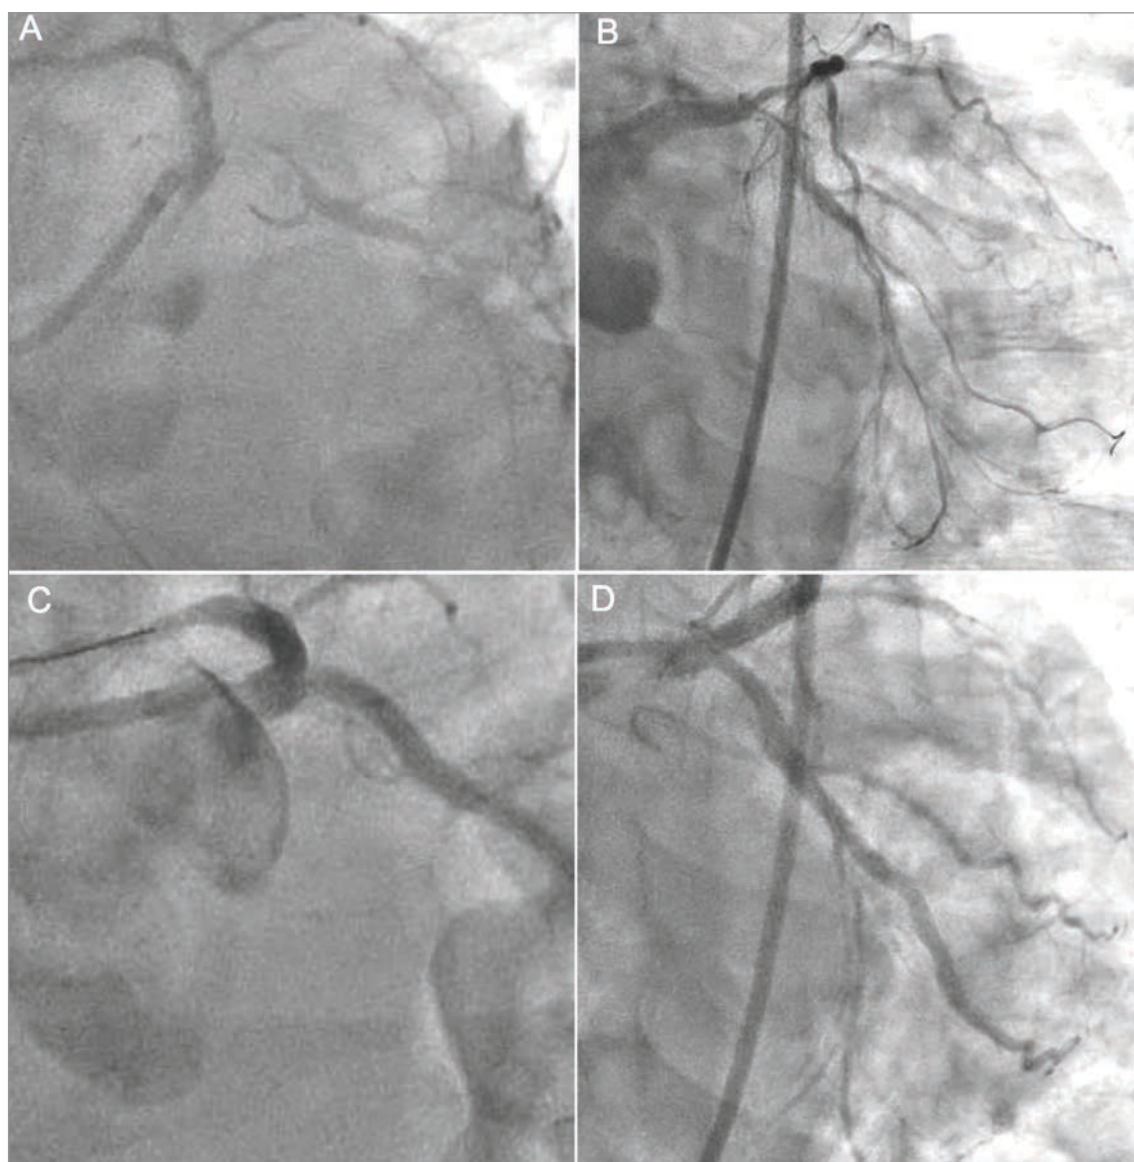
Efficacy of intravascular lithoplasty (IVL). (A-B) Baseline angiography showing severe ostial and proximal circumflex and proximal left anterior descending (LAD) coronary artery disease in an elderly male with class III angina turned down for bypass. IVL was used to treat the ostium of the circumflex and LAD (one balloon in this case, a 4 mm x 12 mm) after predilatation using a non-compliant balloon and then stenting using the DK crush technique with proximal optimization. (C-D) Final angiography in oblique views showing excellent stent expansion. Intravascular ultrasound was used to guide the intervention and care was made not to oversize the ostial/proximal circumflex, given the poststenotic dilatation present at baseline.
